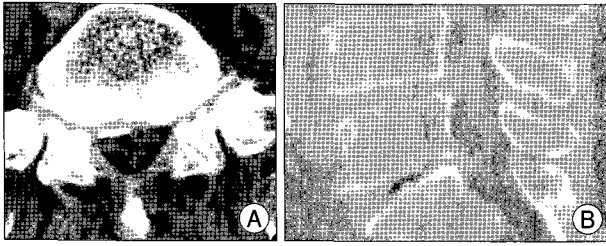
Follow up computed tomography two months later. A : Pneumorrhachis almost disappeared at L5-S1 spinal canal in axial computed tomography. B : Pathway of pneumorrhachis from disc to spinal canal was more obvious than previous study.
